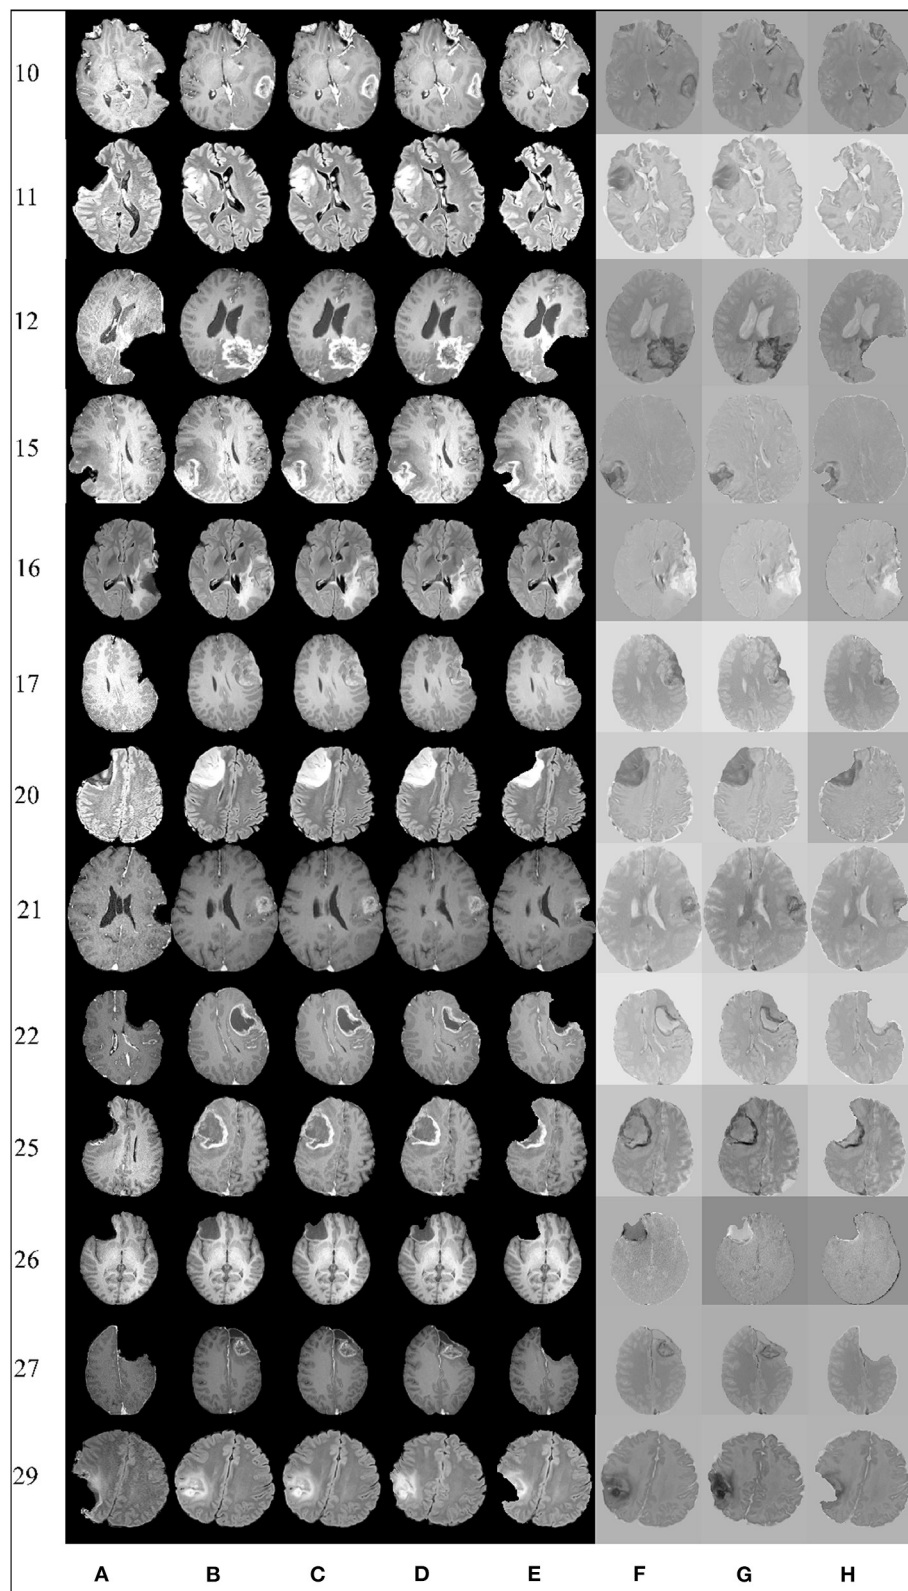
Qualitative results. Each row represents the same slice of a 3D volume for the case numbered on the left. From left to right: intraoperative MRI (A); deformed preop MRI after (B) rigid registration, (C) B-Spline, (D) PBNRR, and (E) A-PBNRR; difference between intraoperative MRI and (F) B-Spline, (G) PBNRR, and (H): A-PBNRR.
